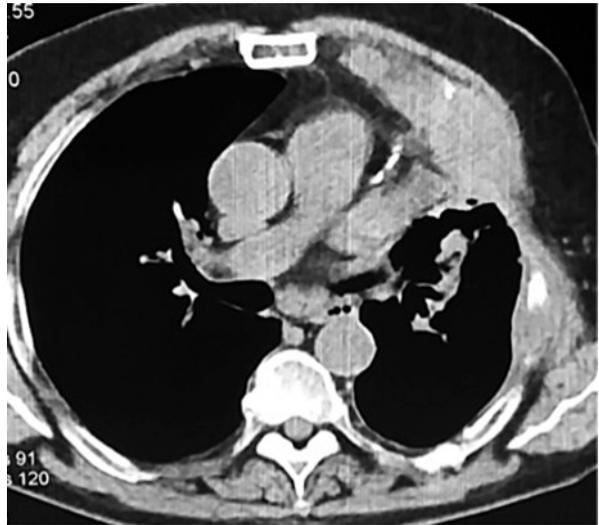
Chest computed tomography (CT) confirmed the presence of a bone metastasis in the frontal side of the fourth rib
